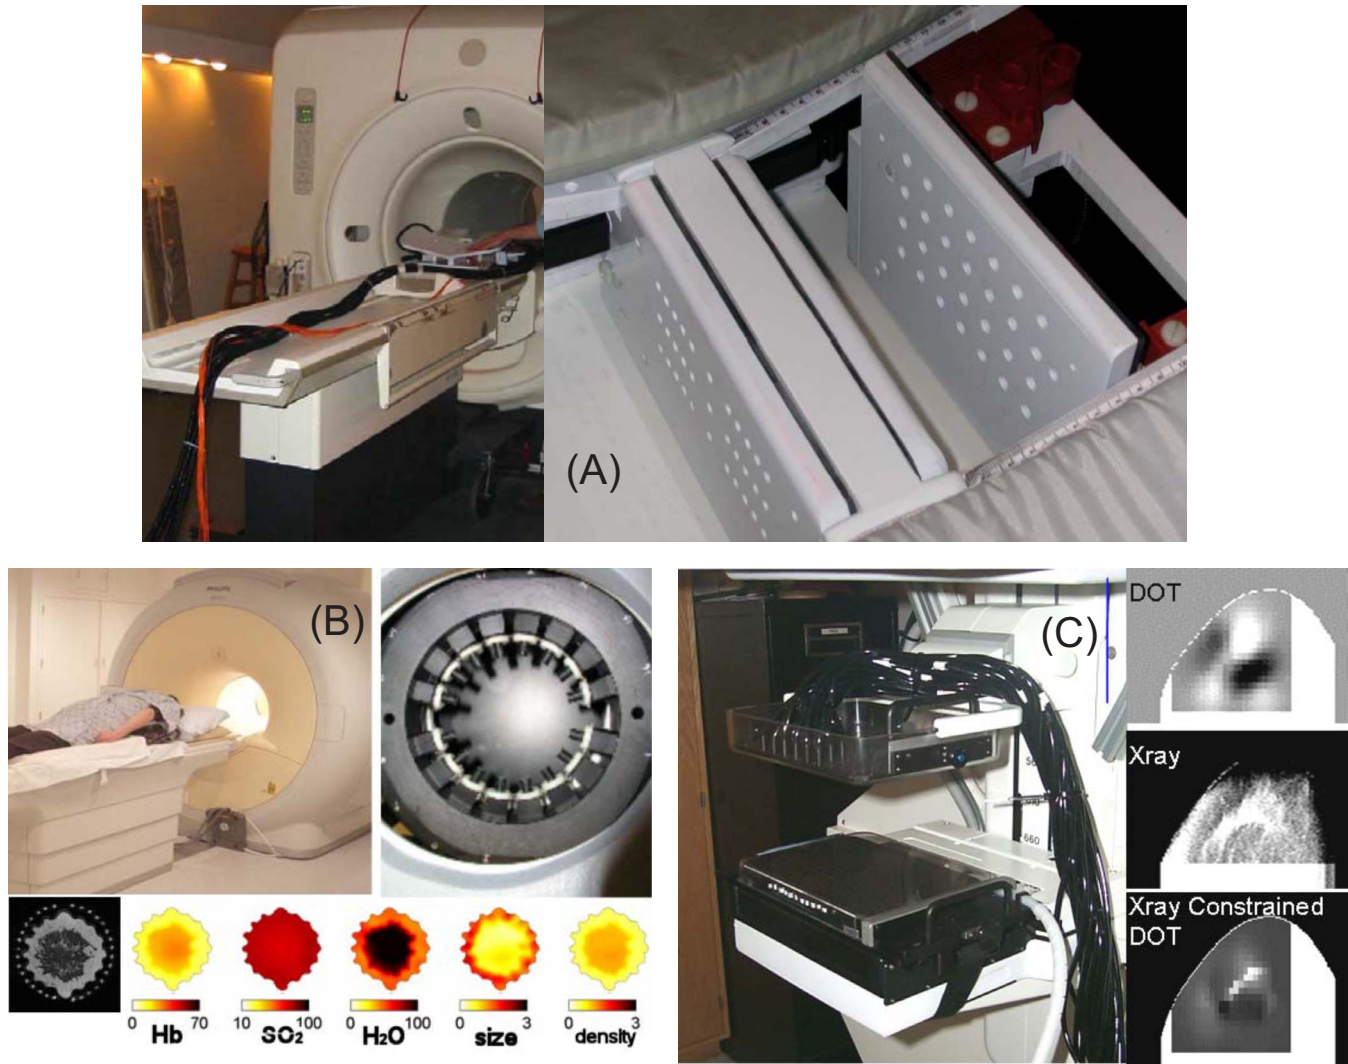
Hybrid Modality systems have been developed and used in pilot clinical trials to characterize tumors and test the synergy in having mutual information and the ability to combine information data sets to create a new class of hybrid images. The University of Pennsylvania system was the first such device (A) (Refs. 26 and 27), and similar systems were built into a 3Tesla MRI at Dartmouth (B) (Refs. 18 and 20), and into an x-ray tomosynthesis system at the Massachusetts General Hospital (C) (Ref. 31).
